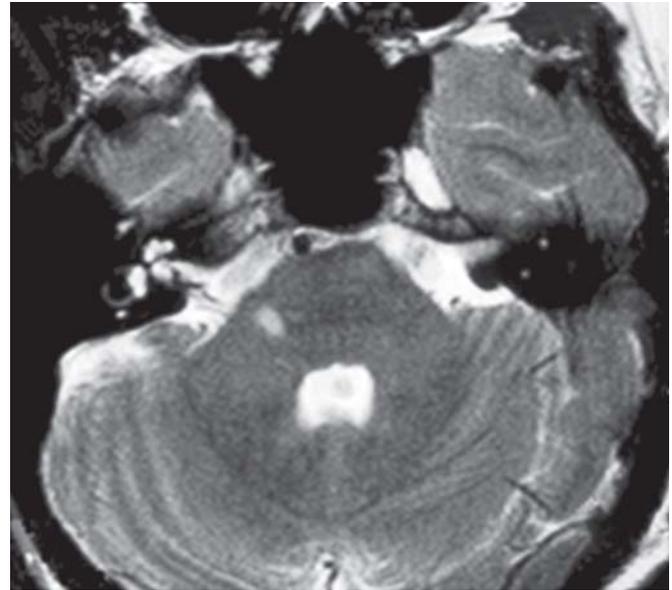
Magnetic resonance image of a patient with vestibular pseudoneuritis, a disorder of the vestibulo-ocular reflex in the yaw plane. The T2-weighted shows an MS plaque in the root entry zone of the eighth cranial nerve on the right side
